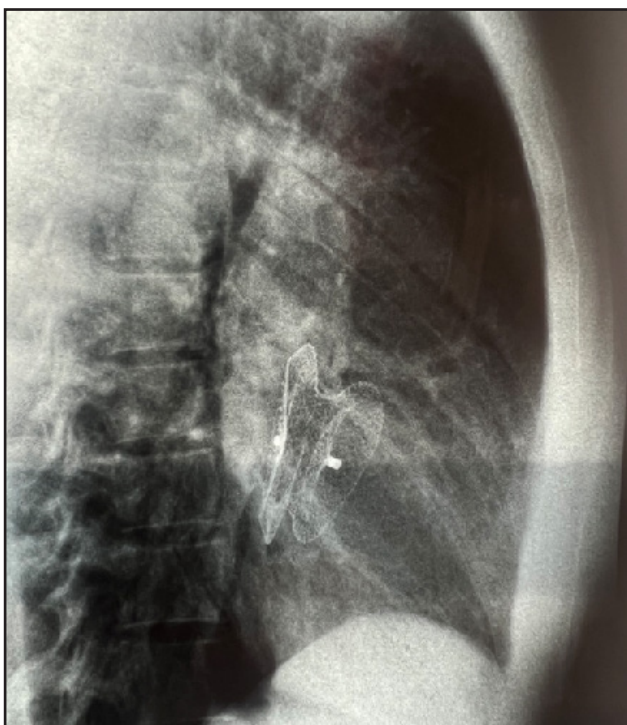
Chest X-ray Lateral view at 3 months follow up.
